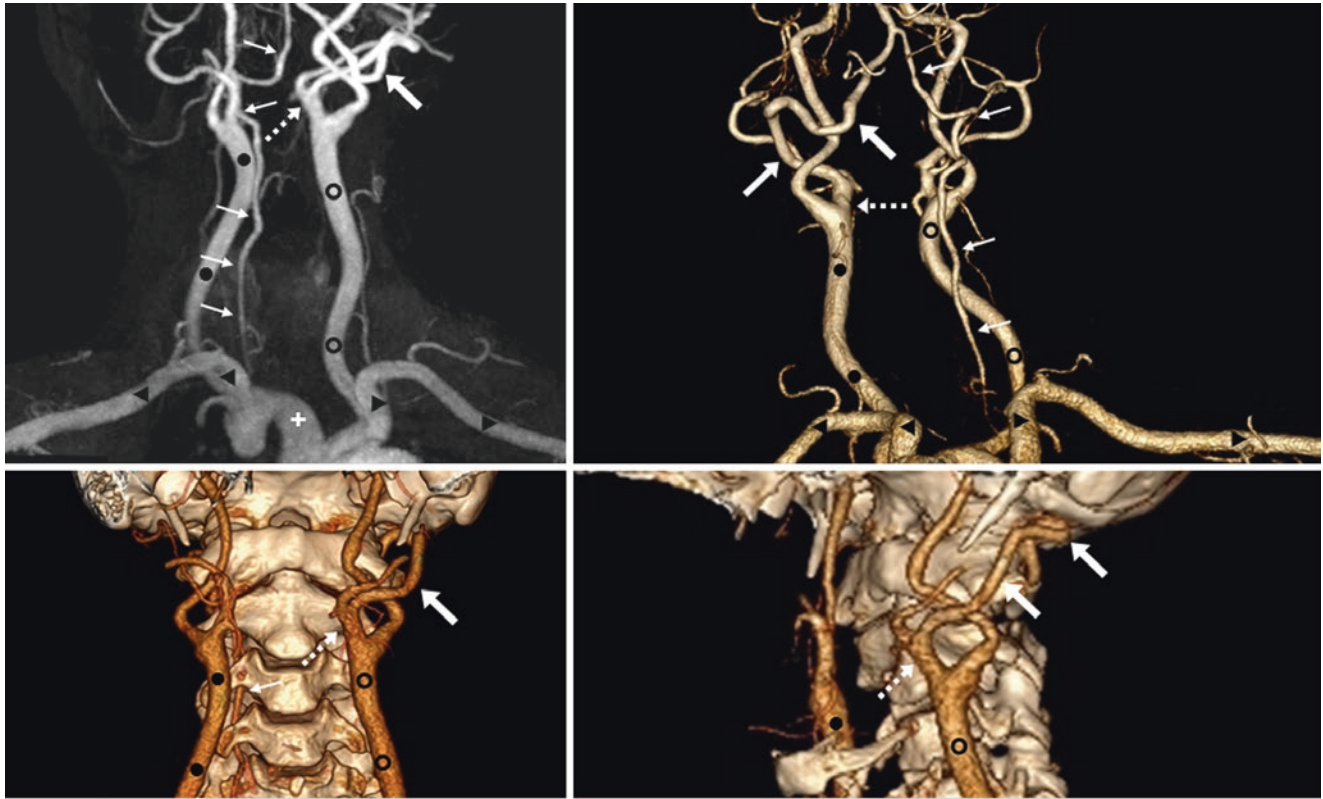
Top row:* 58-year-old with a contrast-enhanced MRA that demonstrates a left vertebral artery (LVA) origin (*large arrows*) that arises from the proximal external carotid artery (ECA, *dotted arrows*) on AP (*left*) and posterior/PA (*right*) views. *Bottom row:* Similar findings are noted on a CTA with AP (*left*) and left lateral (*right*) views. The
